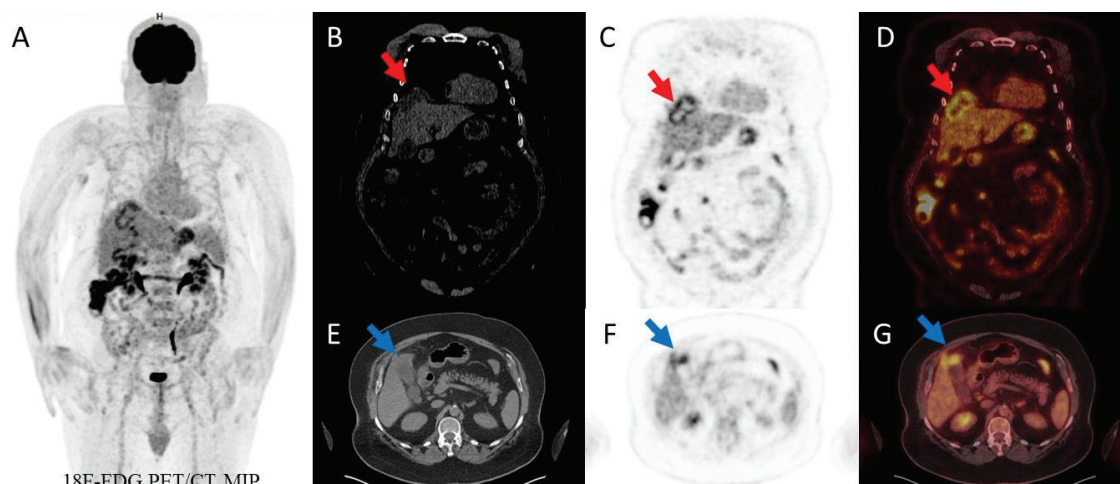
¹⁸F-fluorodeoxyglucose (¹⁸F-FDG) positron emission tomography/computed tomography (PET/CT) imaging was performed to restage maxillary sinus cancer in a 67-year-old man with a known history of diabetes mellitus, hypertension, and stroke (A). In coronal CT sections, there was a hypodense area outside the liver parenchyma at the junction of liver segments 4-8 (B). PET and fusion images (C, D) showed linear ¹⁸F-FDG uptake [maximum standardized uptake value (SUV_{max}): 6.30] (red arrow). Thickening of the fundus was observed in transaxial CT sections (E). ¹⁸F-FDG uptake was observed in PET and fusion images (F, G) (blue arrow). There were several lymph nodes with increased ¹⁸F-FDG uptake in the precaval and aortocaval lymphatic regions (SUV_{max}: 5.40). It was evaluated as a subcapsular abscess secondary to gallbladder microperforation. The clinical findings were indistinct. There was no significant abdominal pain due to diabetic neuropathy. In laboratory tests, neutrophils (7,640/μL), C-reactive protein (CRP) (114 mg/L), alkaline phosphatase (ALP) (134 U/L), gamma-glutamyltransferase (GGT) (87 U/L), and direct bilirubin (0.4 mg/dL) were high. Other liver function tests were within the normal range (aspartate aminotransferase, alanine aminotransferase). He was admitted to the surgical service with a preliminary diagnosis of gallbladder microperforation secondary to cholecystitis.
